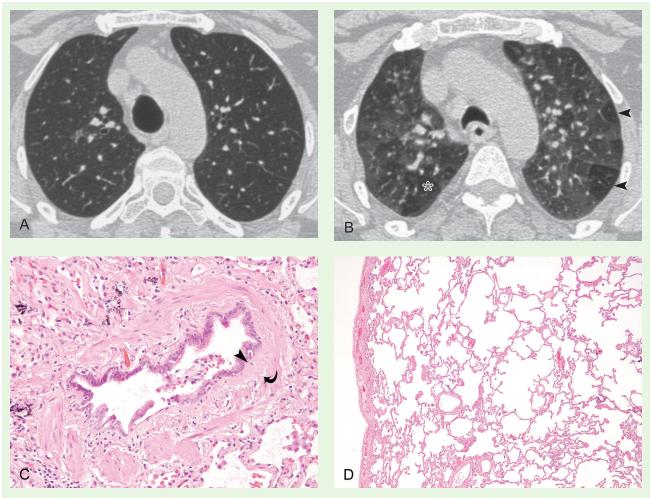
Mosaic attenuation. This 38-year-old female with dyspnea on exertion and normal pulmonary functions demonstrates normal lung parenchyma on this axial high-resolution computed tomographic image (A) acquired through the upper lobes at full inspiration. The expiratory phase image (B) at the same level demonstrates multiple, lobular (*arrowheads*), and larger (*asterisk*) regions of low attenuation consistent with air-trapping. In the same patient, the open lung biopsy demonstrates a prominent layer of fibrous tissue (C) between the bronchiolar epithelium (*arrowhead*) and the smooth muscle layer (*curved arrow*); normally, the bronchiolar epithelium rests directly on the smooth muscle layer. Airway fibrosis in constrictive bronchiolitis is typically present in a background of essentially normal lung parenchyma (D).
